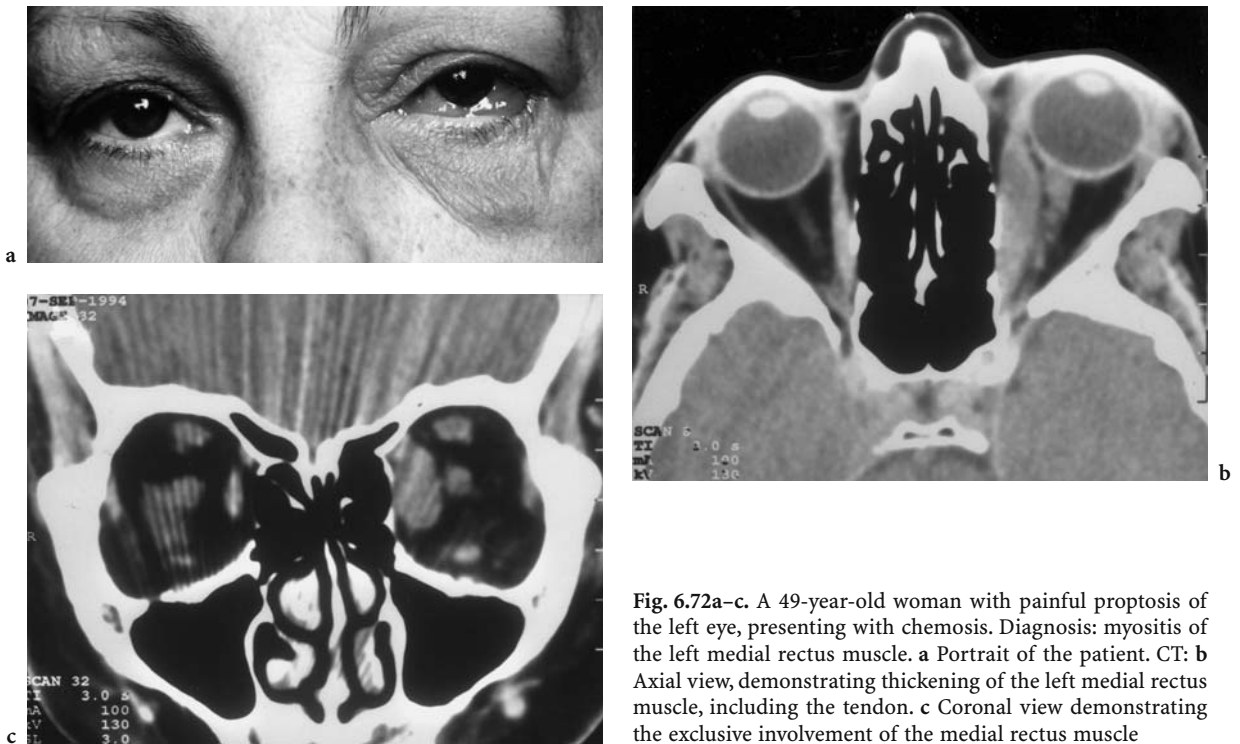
A 49-year-old woman with painful proptosis of the left eye, presenting with chemosis. Diagnosis: myositis of the left medial rectus muscle. a Portrait of the patient. CT: b Axial view, demonstrating thickening of the left medial rectus muscle, including the tendon. c Coronal view demonstrating the exclusive involvement of the medial rectus muscle
